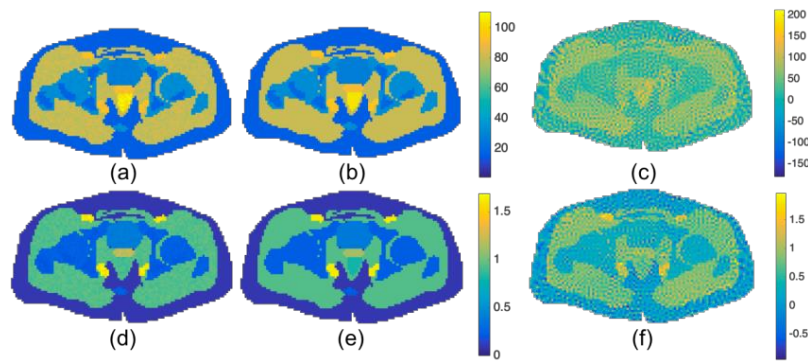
In-vivo* EPs estimation by processing MRI data: Reference (a)-(d) and retrieved permittivity and conductivity profiles for the pelvis scenario respectively with T_n basis (b)-(e) and pixel basis (c)-(f) (SNR = 40dB).
